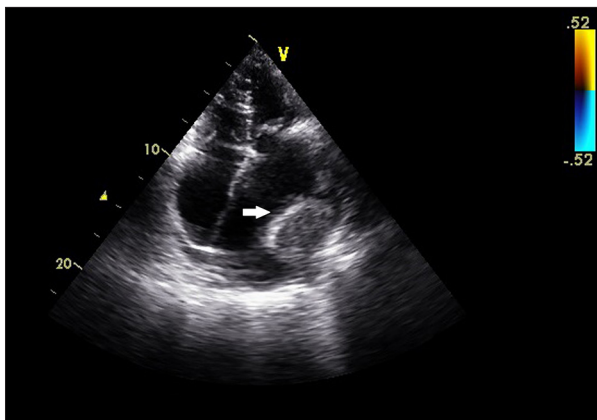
2D transthoracic echo showing large left atrial clot (white arrow).
